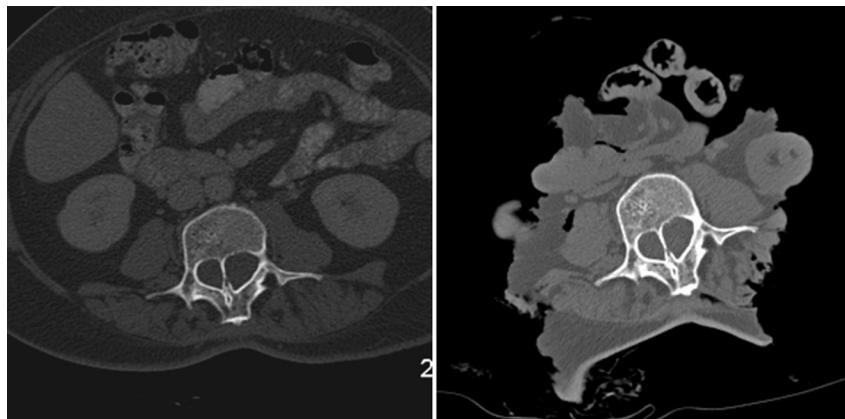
Comparative pre mortem (right) and post mortem (left) CT imaging demonstrating the duplicate spinal canal.
